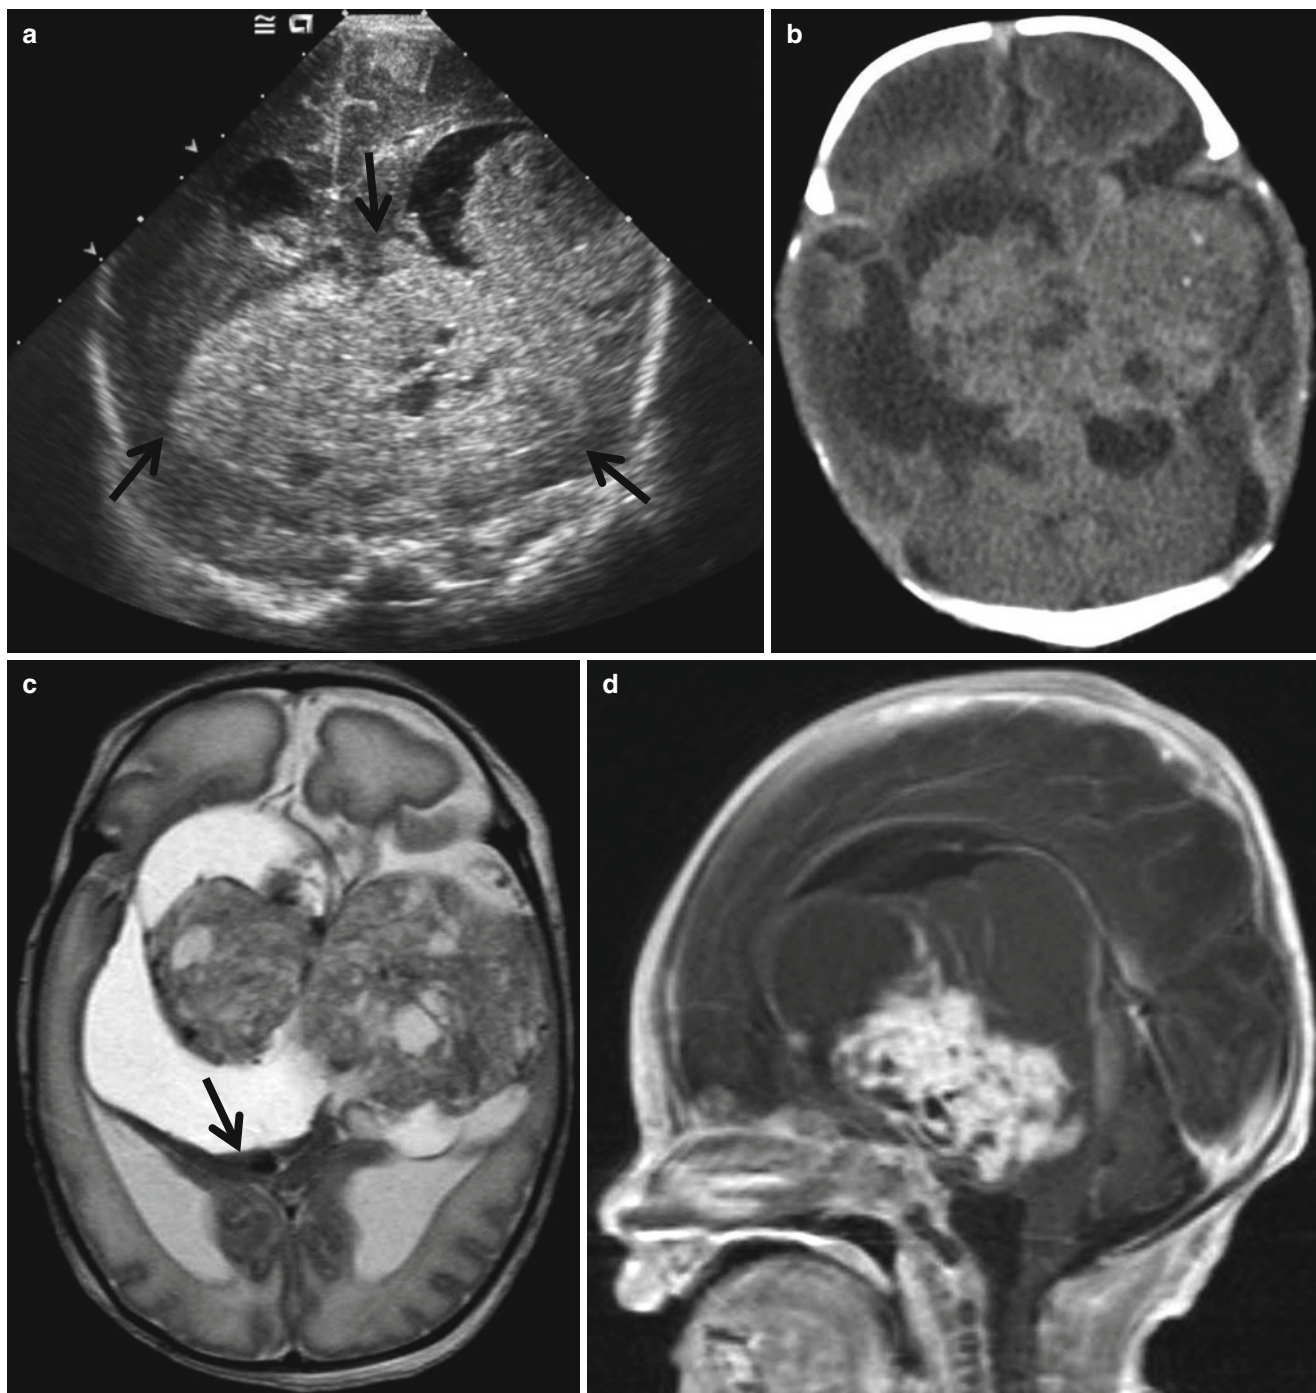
Congenital immature teratoma in a neonate. (a) Brain sonography shows huge echogenic mass (arrows) with ventriculomegaly. (b) CT scan reveals a large solid and cystic mass with tiny calcifications occupying the central portion of the brain. (c) The solid portion is heterogeneously isointense on T2-weighted image containing signal
